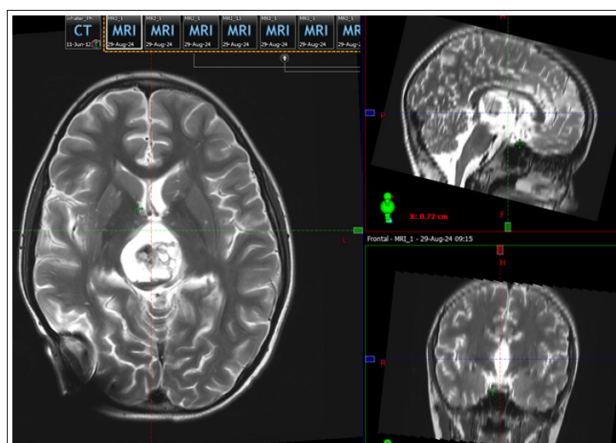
Cerebral MRI/ August 2024 - In the Area of the Dorsal Part of the Third Ventricle and Cranially from the Mesencephalon, an Oval Tumor Lesion with a Heterogeneous Structure is Visualized with the Presence of Solid and Cystic Components and Calcifications. The Cystic Components have a High Colloidal Content with Liquid Levels. After Intravenous Administration of Contrast Material, the Finding Increases its Signal Intensity Inhomogeneously.
